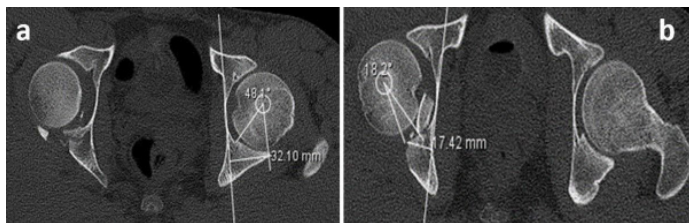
The preoperative measurements. The photograph of computed tomography imaging intact (a) and fracture (b) posterior wall in our case.
